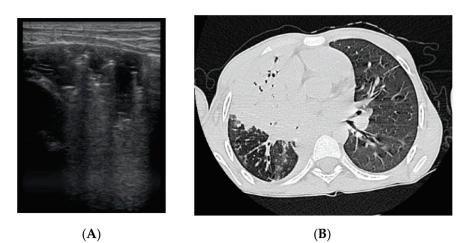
(A) LUS: coalescent B lines, loss of A lines. (B) CT image: (1) cylindrical bronchiectasis with moderate wall thickening; (2) varicose bronchiectasis; (3) saccular bronchiectasis with moderate wall thickening; and (4) several bronchiectasis with mucus plugging.
